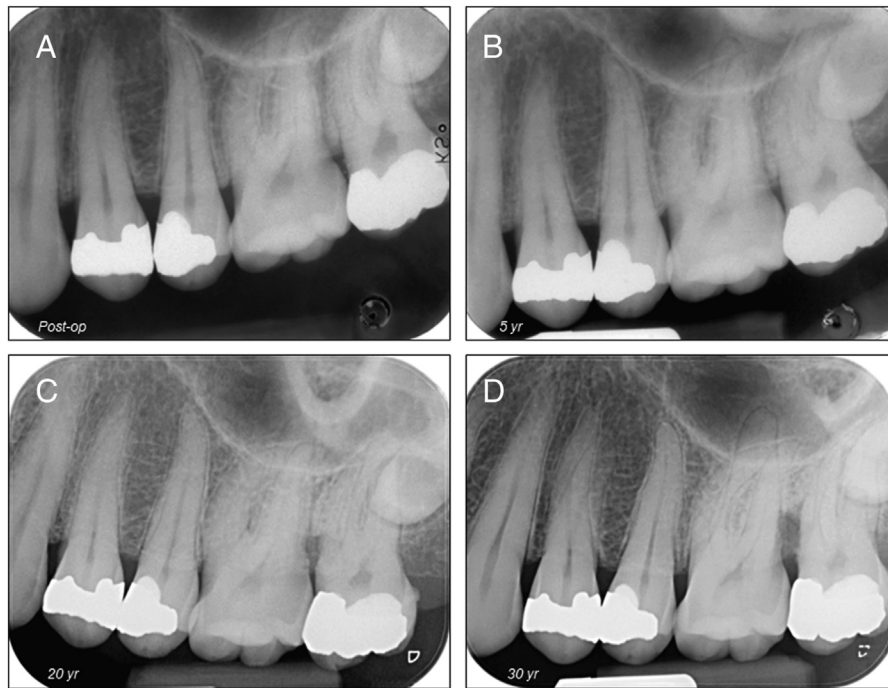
32-year-old woman with deep caries in the upper left quadrant. Small pulp exposures of the mesiobuccal pulp horns occurred for teeth #13 and #15. Bleeding time < 3 minutes. Capping with Dycal. Zinc phosphate cement was used as an intermediate base and cavities were restored with amalgam. (A) Postoperative radiograph. (B–D) Follow-up radiographs taken respectively after 5, 20, and 30 years. Cases were assessed as success. Pulp responded normally to sensibility tests. Normal periapical conditions. Absence of pathologic calcifications. Reduction of the pulp volume of teeth # 13 and # 15 is not dissimilar to that of neighboring teeth. Note the periodontal bone loss between teeth #14 and #15 in the long term.
